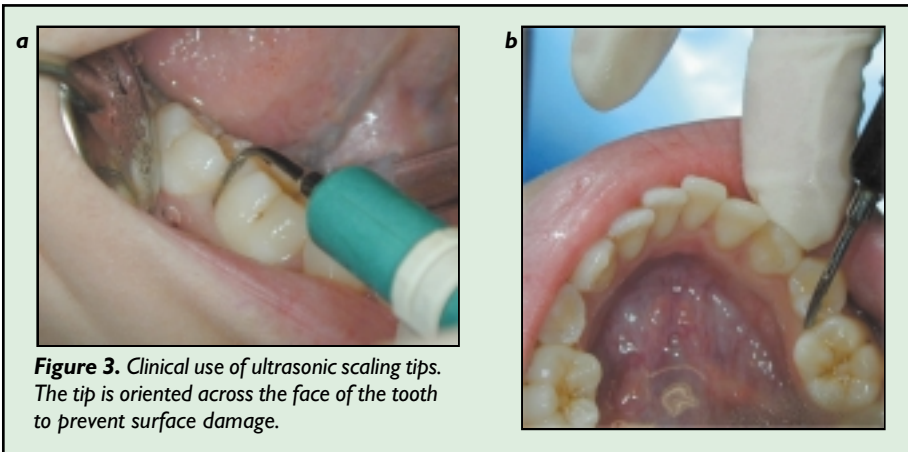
Clinical use of ultrasonic scaling tips. The tip is oriented across the face of the tooth to prevent surface damage.
